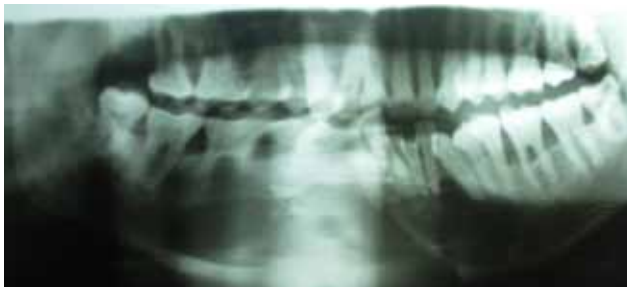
Panoramic radiograph reveals a multilocular radiolucency extending from 47 to 35 region, crossing the midline, there are radiopaque septae present in the radiolucency. Root resorption in 46 with displacement of 44, 43, 31, 33, 34, and 35. There is generalized alveolar bone loss.
